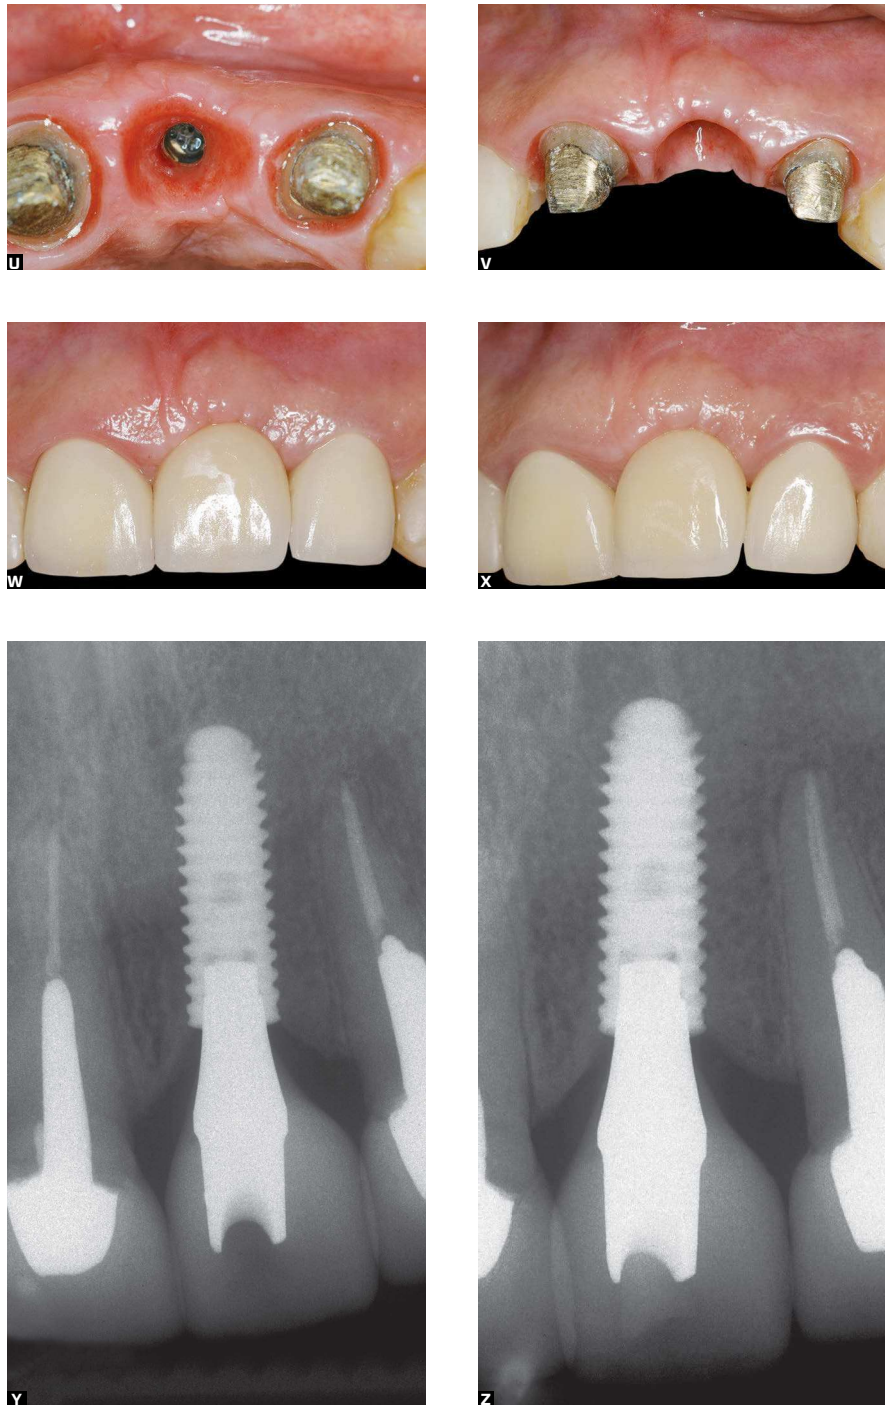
U) Clinical aspect of gingiva at time of crown placement, showing space for prosthesis contour and emergence profile, and concave arch regular configuration (V). W) Placement of definitive crowns. Y) Immediate radiographic control. Notice biological concave profile of prosthetic abutment. X, Z) Clinical and radiographic 2 years follow-up. Notice gingival and bone stability.
